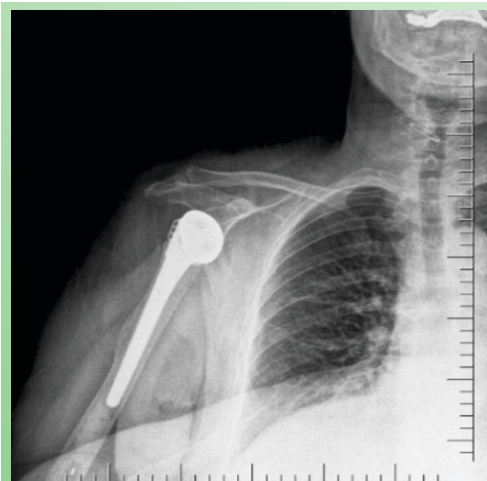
Immediate Post-operative X-ray Showing Satisfactory Cemented Hemiarthroplasty of the Right Shoulder.
